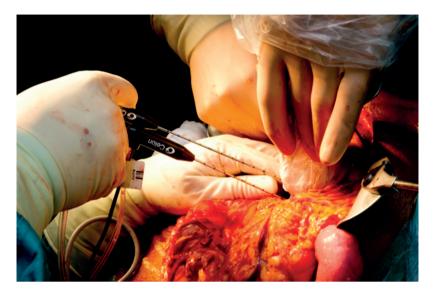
Intra-operative placement of RFA probe under direct ultrasound guidance
